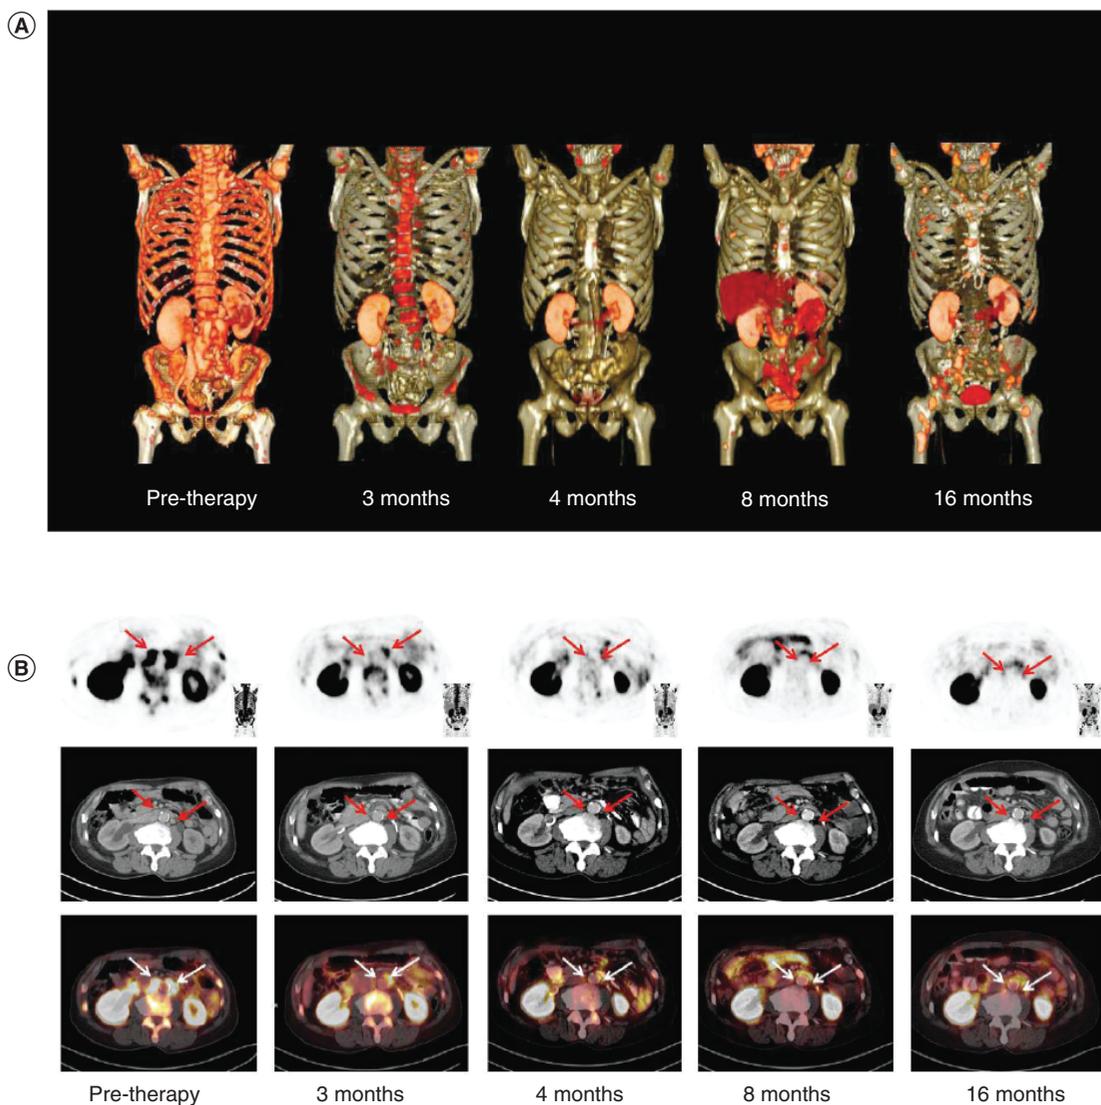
Summary of outcomes in patient 15 after treatment with pasotuxizumab. For patient 15, a compilation of representative PSMA PET/CT 3D whole-body views (A) and transaxial ⁶⁸Ga-PSMA PET (top row (B); inserts, PET maximum intensity projections), CT (middle row (B)) and fused PET/CT (bottom row (B)) slices at different time points during treatment with pasotuxizumab. CT: Computed tomography; ⁶⁸Ga: Gallium-68; PET: Positron emission tomography.
